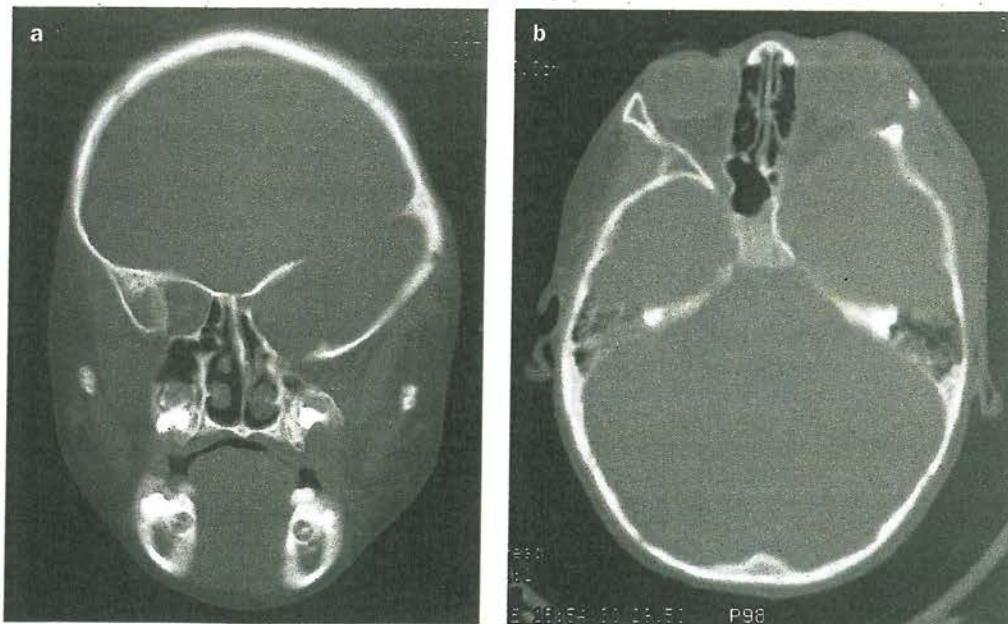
CT scan showing congenital absence of the left greater wing of the sphenoid bone. (a) Coronal view; (b) axial view
